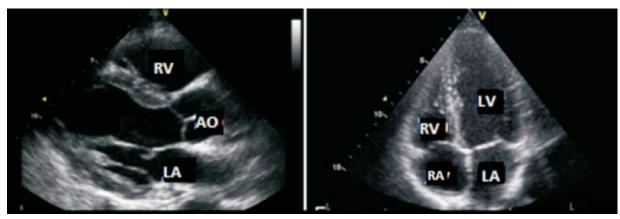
The echocardiography examination at the 7th day from admission.
